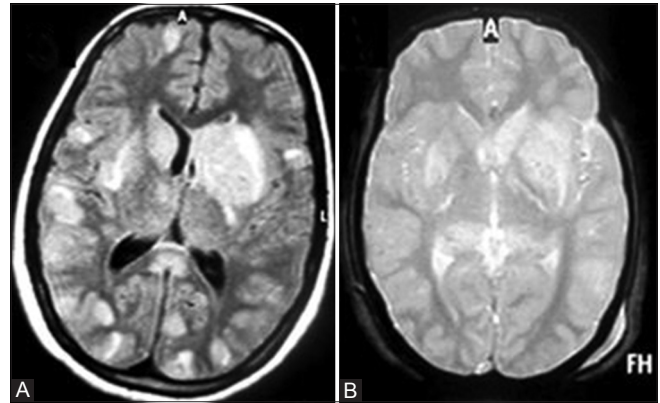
(A and B): (A) Axial FLAIR and (B) gradient echo (GRE) MR images at the level of basal ganglia show multifocal FLAIR hyperintense lesions at gray-white matter junction and in bilateral basal ganglia. None of the lesions shows evidence of hemorrhage (B)
